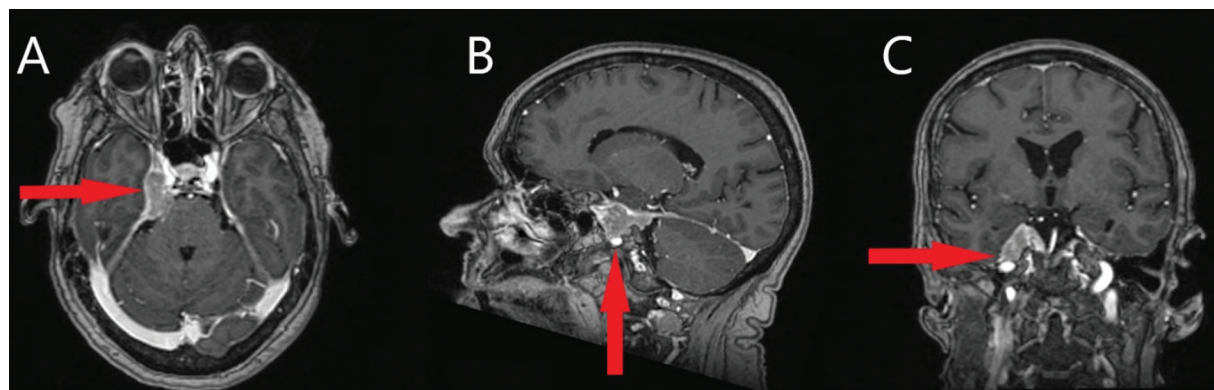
T1-weighted magnetic resonance image; (A) axial, (B) sagittal, and (C) coronal views showing an expansive lesion in the trigeminal cistern on the right, extending to the tentorium, cavernous sinus, and inferiorly to the Gasser ganglion, with contrast enhancement.
